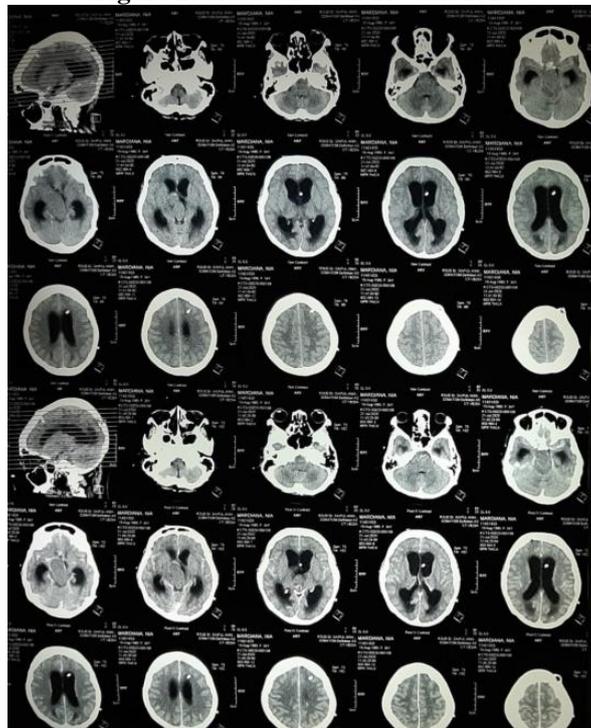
Head CT-Scan 21<sup>st</sup> Juli 2020
